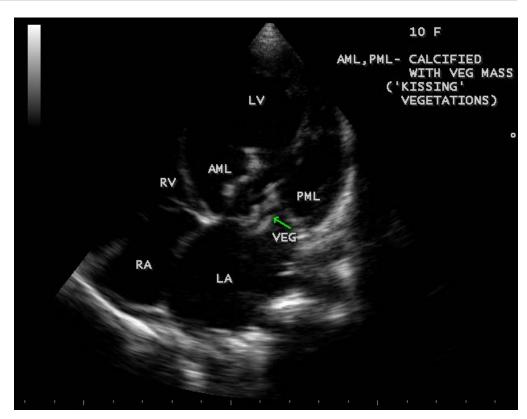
Vegetation seen as "kissing" type in apical four chamber view.
